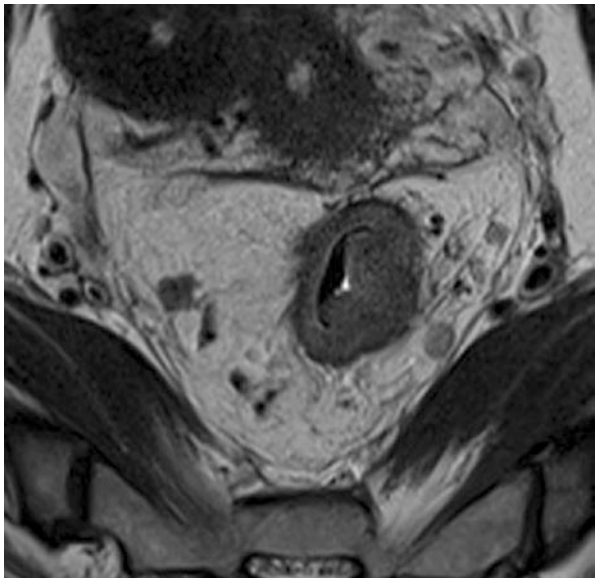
Axial T2 MRI demonstrates variable mesorectal node appearance. Reactive node at 4 o'clock with smooth margins and T2 hyperintensity versus malignant node at 9 o'clock with heterogeneous signal intensity and irregular margins
